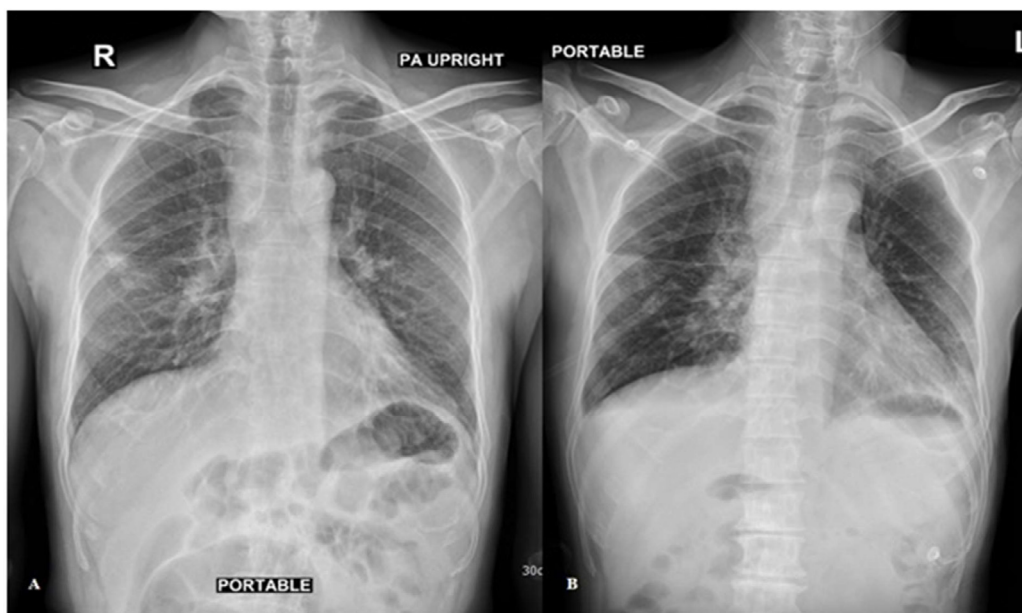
Chest radiography showed nodular infiltration at lateral segment of right middle lobe and thickening of right paratracheal area (A), and developed minimal bilateral pleural effusion with increasing enlarged mediastinal area especially right paratracheal area after initial antibiotic treatment (B).
